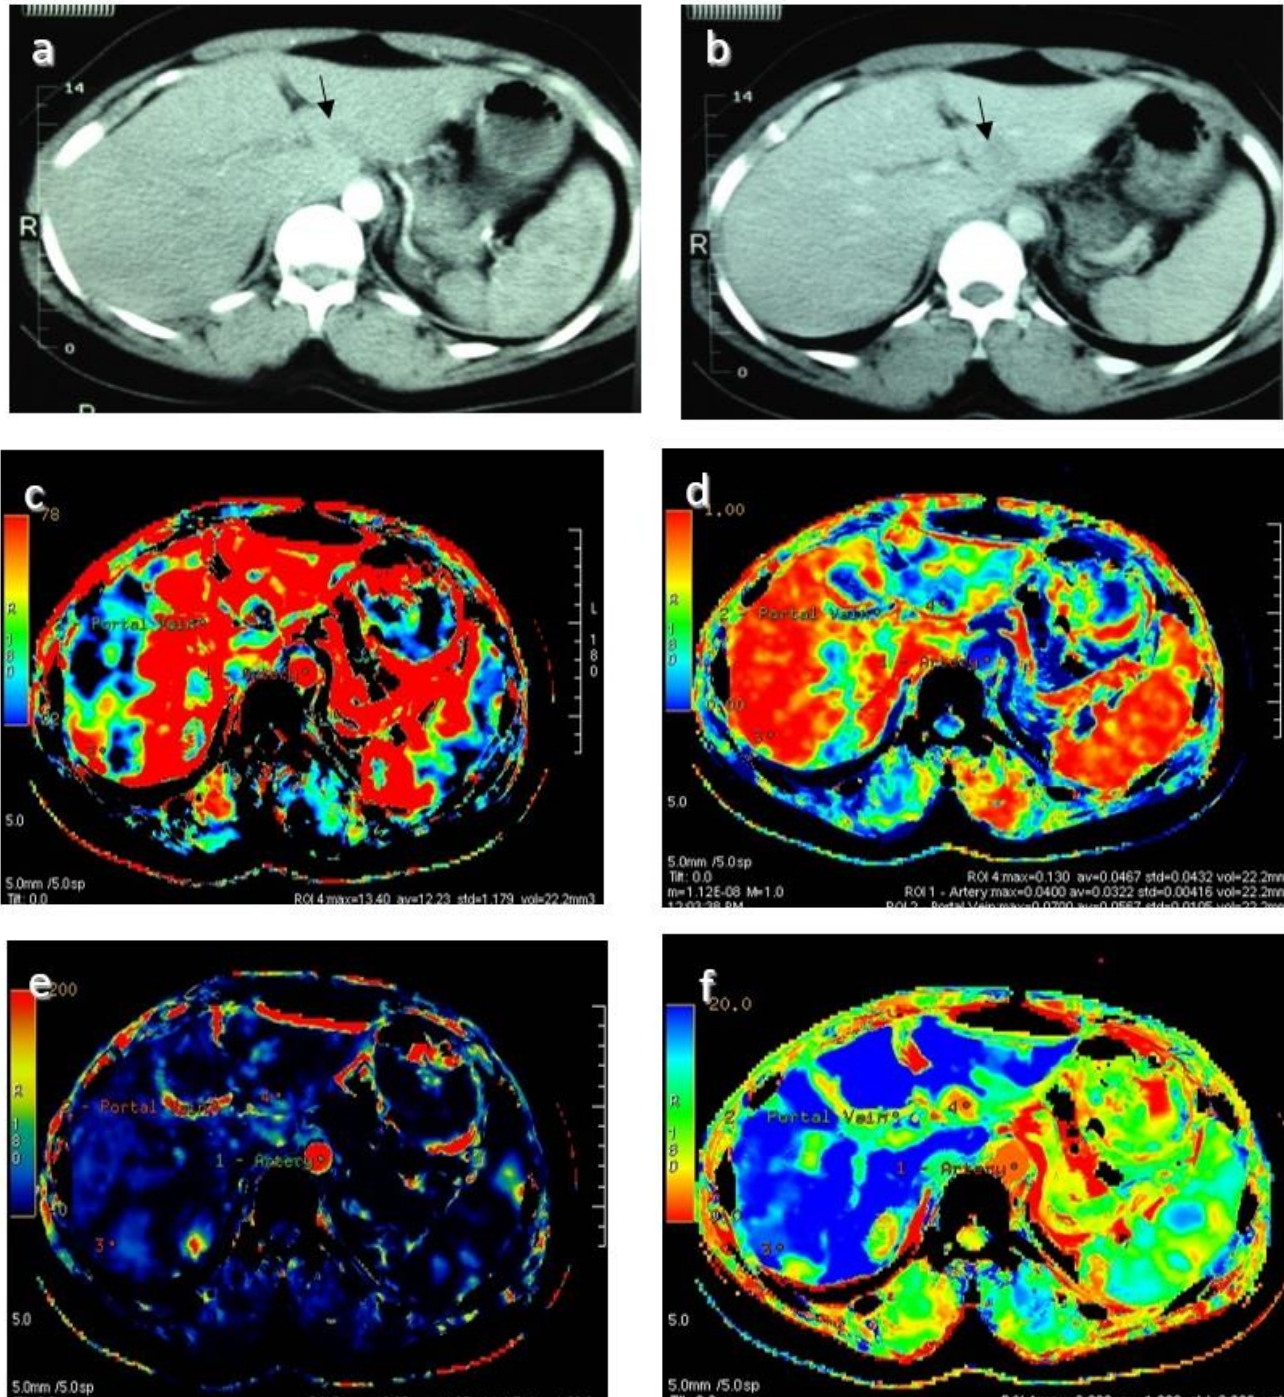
Hepatic focal lesion diagnosed as metastatic adenocarcinoma by biopsy. (a) Arterial (a) and portal (b) phases of postcontrast CT showed no enhancement of the lesion (arrow). (c) BV map. (d) BF map. (e) PS map. (f) MTT map. BV, BF, PS, and MTT of the hepatic focal lesion were 12.2, 240.8, 6.9, and 1.9, respectively. BV, BF, PS, and MTT of the background liver were 54.1, 180, 60.9, 14.29, and 18.2, respectively.
